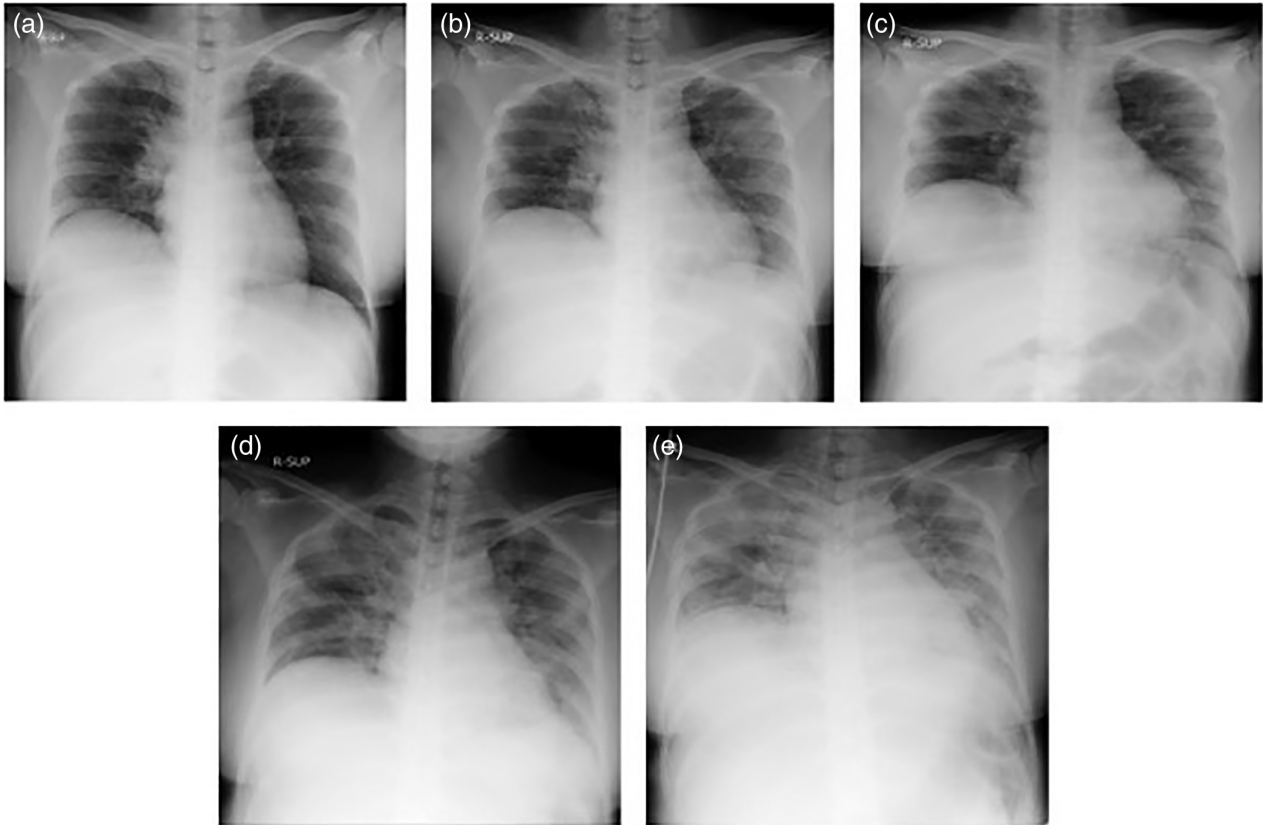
Chest radiograph. (a) Image on day 0 of week 26 showing a slight decrease in permeability. (b) Image on day 2 of week 26 showing a greater decrease in permeability than that in (a). (c) Image on day 4 of week 26. (d) Image on day 5 of week 26. (e) Image on day 6 of week 26 showing ground-glass shadows on both lung fields and a gradual decrease in permeability over time.
